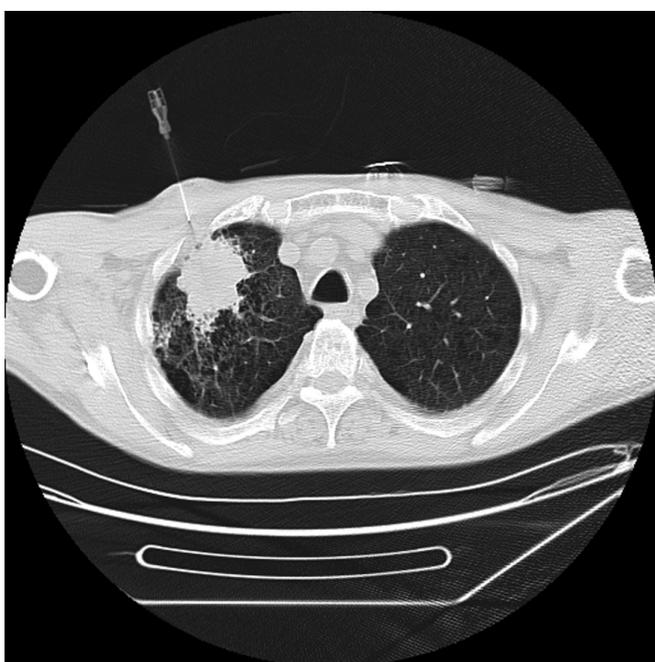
Axial computed tomography obtained in preparation for biopsy with the needle on the chest wall.
